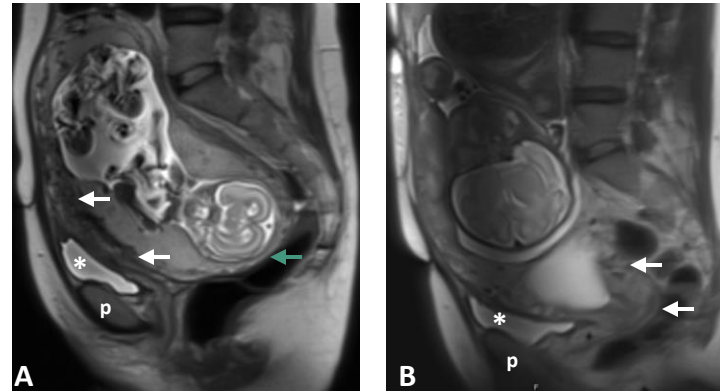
Sagittal T2-weighted MRI at 19 (A) and 31 (B) weeks gestation. A) A retroverted gravid uterus with the uterine fundus (green arrow) trapped below the sacral promontory. The cervix (white arrow) is elongated anteriorly and superiorly. The urinary bladder (*) is displaced superiorly to the pubic symphysis (p) and compressed anteriorly. B) Normal anteverted position of the gravid uterus.
